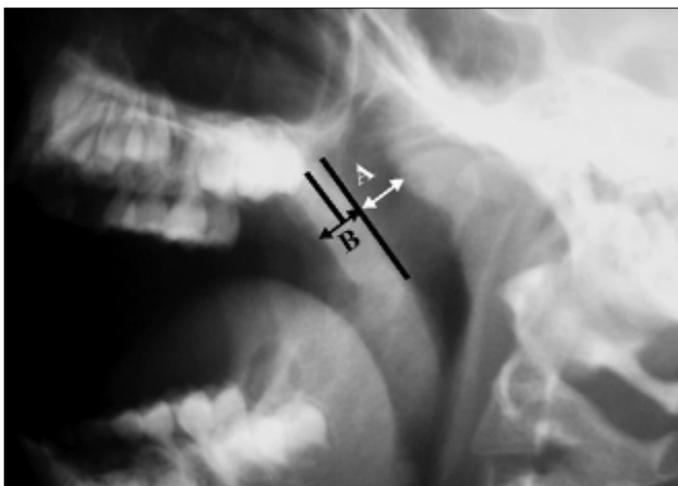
Radiographic evaluation of adenoid size by the method of Cohen and Konak (9). Thickness (mm) of "Airway column" (A) and "Soft palate" (B) is measured and A/B ratio is calculated in order to evaluate nasopharyngeal airway patency
